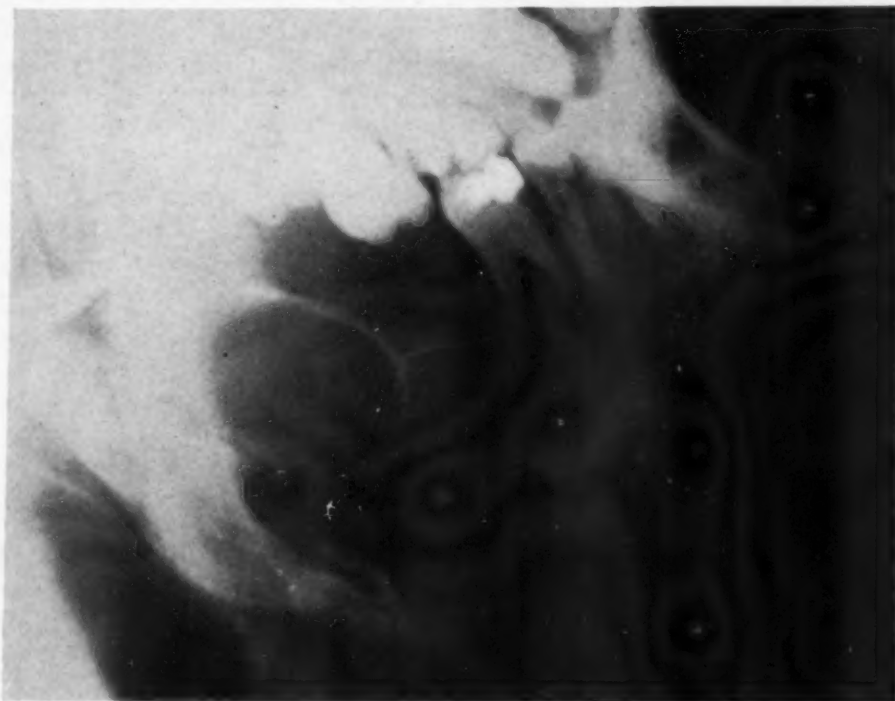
X-ray of multilocular cyst.
